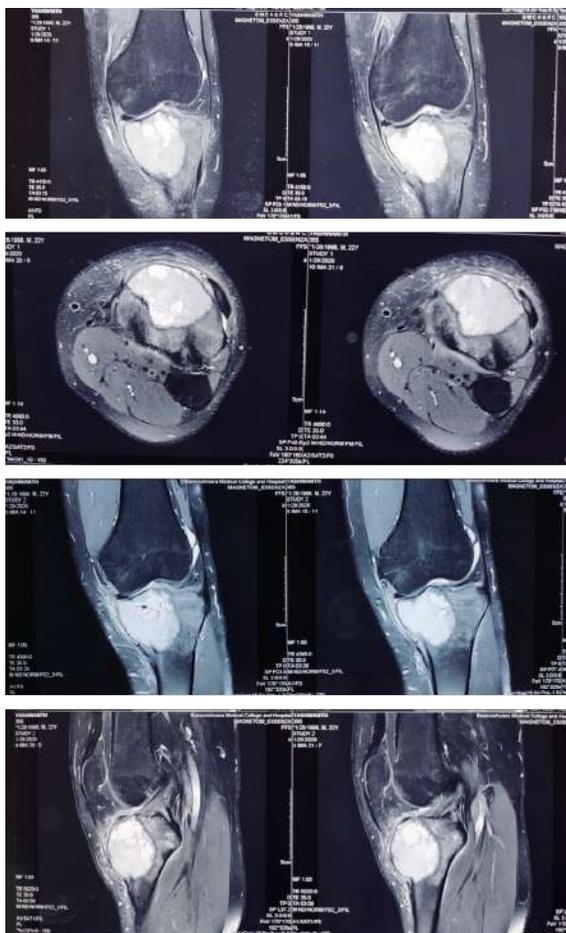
MRI Left knee and leg
